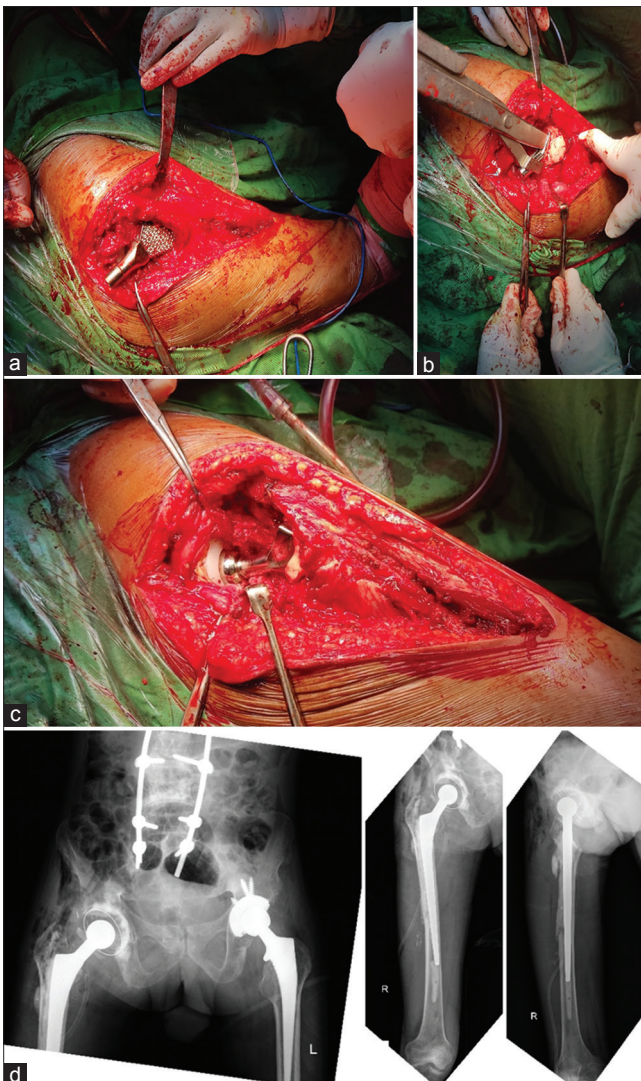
Intraoperative clinical condition (a-c) and post-operative X-ray (d)
